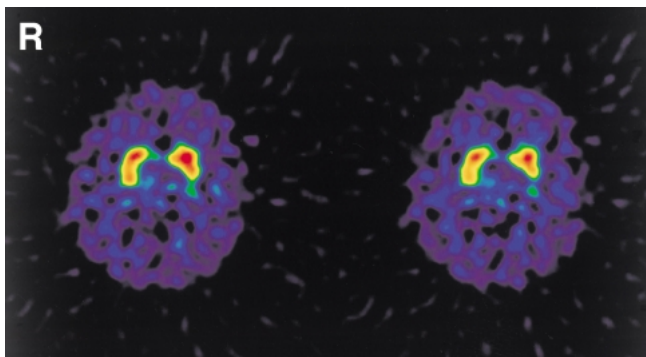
¹²³I-beta-fluoropropyl-2beta-carbomethoxy-3beta-(4-iodophenyl)tropane-single photon emission computed tomography images demonstrating normal presynaptic dopamine reuptake in the bilateral putamens and caudate nuclei.
